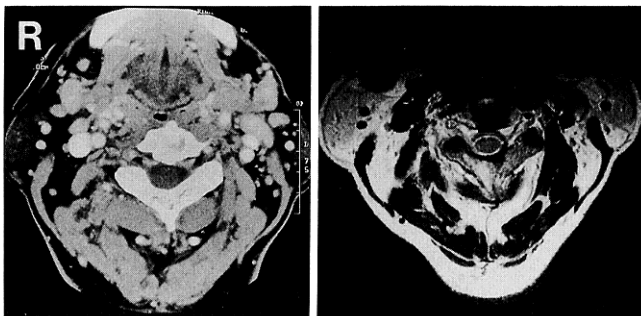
Computed tomography scan with contrast medium (*left*) and  $T_2$ -weighted magnetic resonance image (*right*) after treatment showing shrinkage of the epidural veins and restoration of the normal configuration of the spinal cord and cerebrospinal fluid space.
